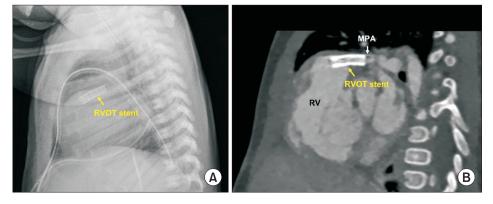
Postoperative morphology of the right ventricular outflow tract (RVOT) stent. (A) Immediately postoperative chest X-ray. (B) Postoperative computed tomography obtained 4 months after the hybrid procedure. MPA, main pulmonary artery; RV, right ventricle.
